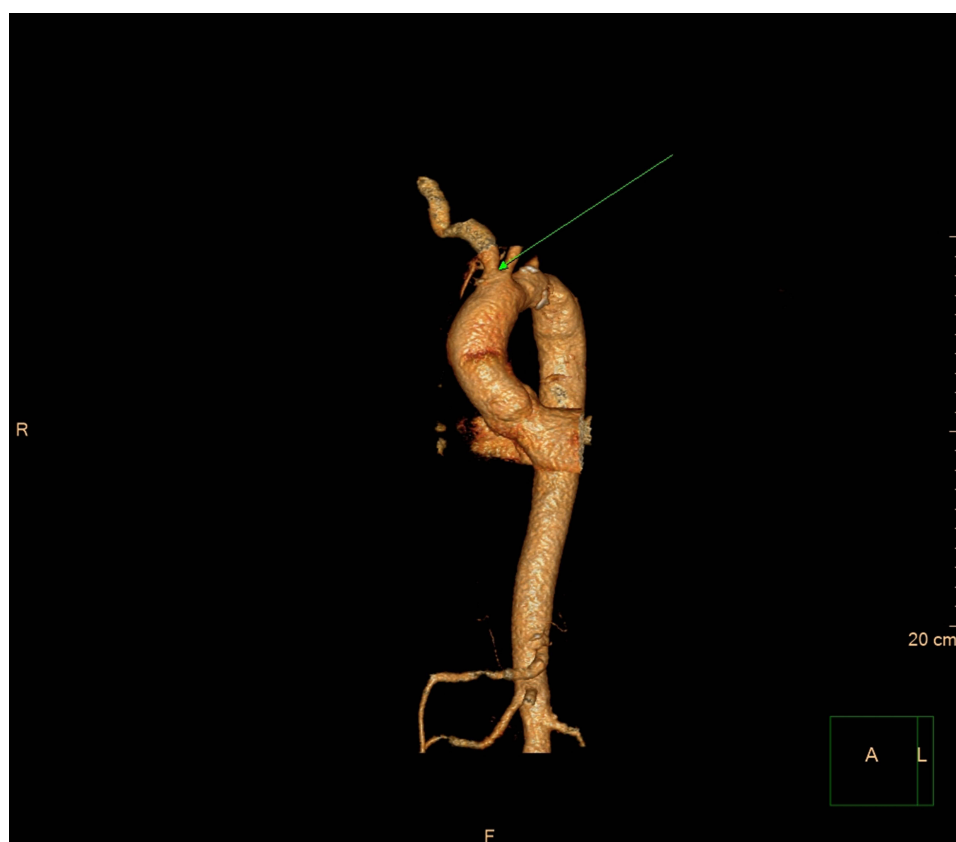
3D construction of the CT angiography indicating left subclavian stenosis at the origin (by arrow).
